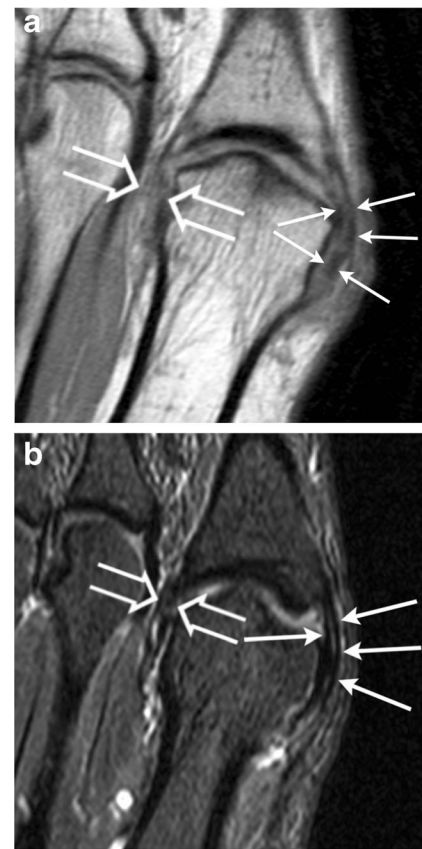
47-year-old female volunteer with heterogeneous signal of the collateral ligament complex. The medial collateral ligament (*arrows*) and lateral collateral ligament (*open arrows*) demonstrate hypointense, isointense, and hyperintense areas on a coronal intermediate-weighted MR image (A). The accessory medial collateral ligament (*arrows*) and accessory lateral collateral ligament (*open arrows*) show hyperintense areas on the coronal STIR MR image (B)
